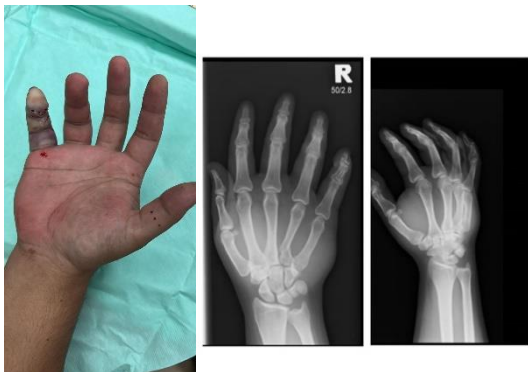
Right hand x-ray showing comminuted fracture P2 little finger and base of 4th/5th MCB
